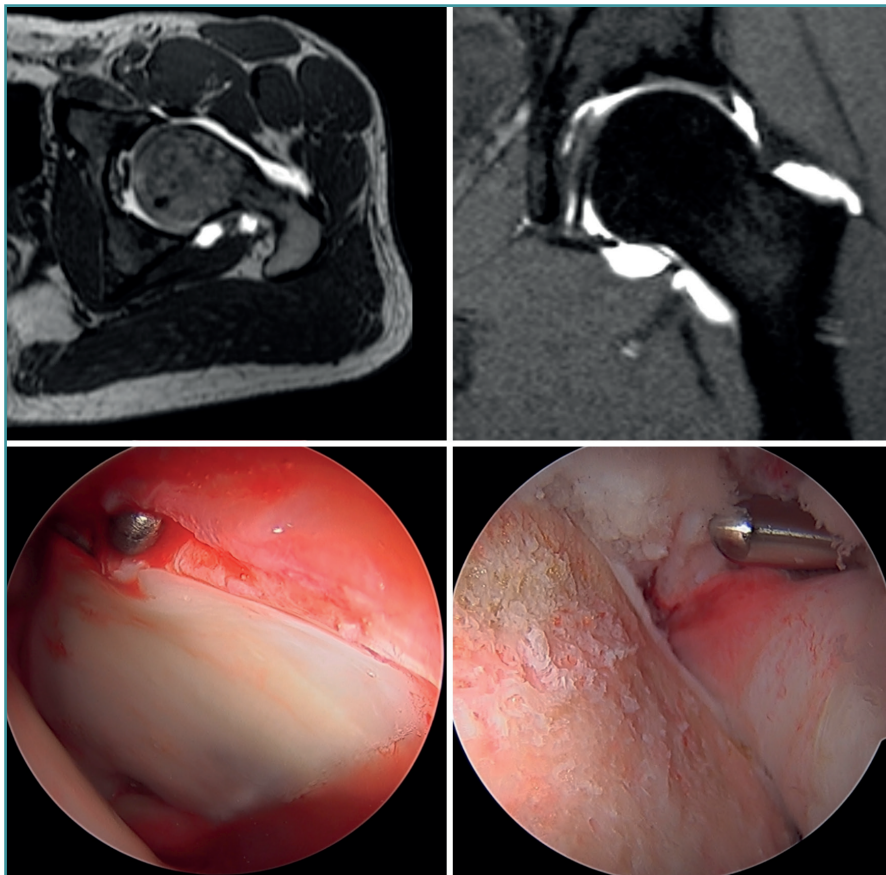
Combined femoroacetabular impingement in a middle-aged male patient. At top, axial and sagittal views of the preoperative MRI study, showing a deformity at the head-neck transition (left) and a chondrolabral junction lesion with excess coverage in the upper area (right). At bottom, intraoperative details of the chondrolabral junction lesion (left) and correction of the femoral deformity (right).
